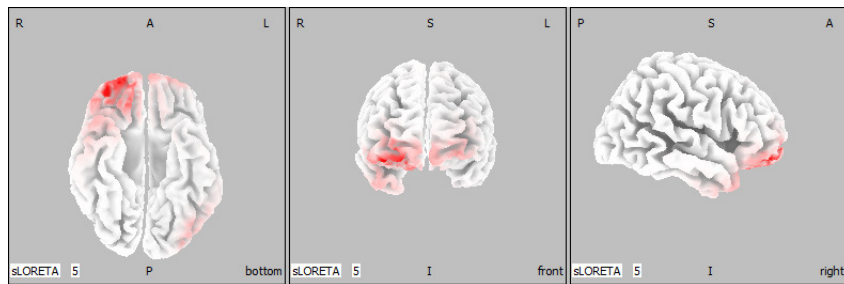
displays the current density field of patient 2 in delta band. The pictures show that the application of LORETA to HD-EEG allows to detect sources that are not revealed by the 10–20 configuration. In Figure 3.20a, only the frontotemporal area is active. In Figure 3.20b, a frontoparietal activity in both hemispheres appears. Finally, Figure 3.20c highlights a greater activation in the left frontoparietal area and the sources of the frontotemporal regions previously detected by the 10–20 electrode configuration become barely visible. Also in this case, the images obtained with the 173-channel EEG agree with the structural maps generated by the MRI of patient 2, whose gliotic lesions are placed near the left frontoparietal region.
